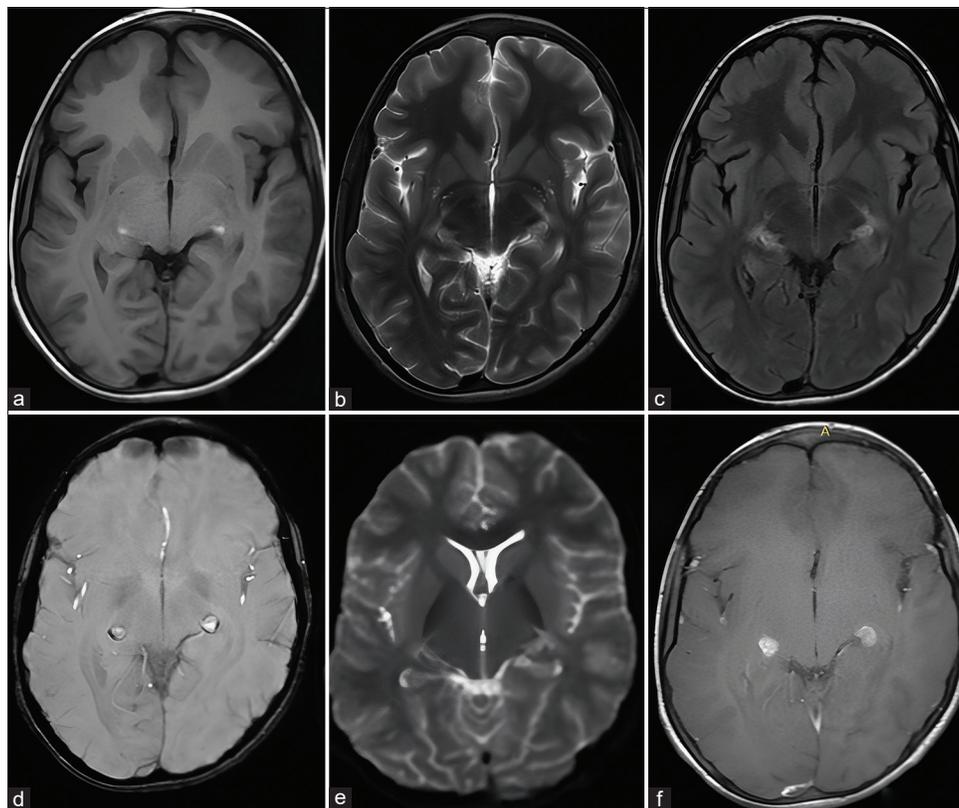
Axial MRI brain images show area of altered signal intensity in bilateral lateral geniculate bodies extending into optic radiations which appears bright on T1(a), hyperintense on T2/FLAIR(B&C), show peripheral blooming on FFE(d), no evidence of any diffusion restriction(e) and show solid contrast-enhancement on post-contrast imaging(f).
